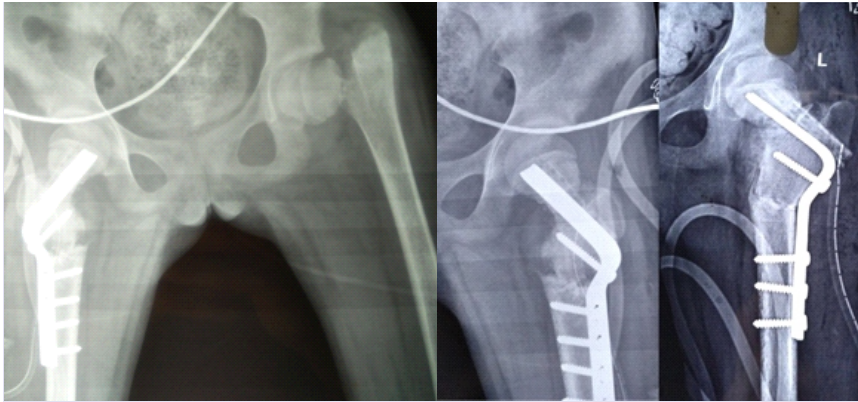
Post-operative radiographs showing open reduction & internal fixation with valgus osteotomy, angled blade plates & Fibula grafting.
